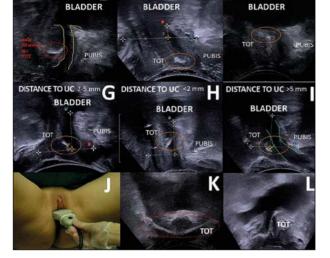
Ultrasound parameters for evaluating the placement and function of tension-free suburethral slings: transperineal ultrasound in the sagittal plane (A), which enables evaluation of the position of a transobturator tape (TOT) at rest (B), and urethral kinking during the Valsalva maneuver (C); position (D, middle third; E, distal third; F, proximal third); distance to the periurethral complex (UC) (G, 3-5 mm; H, < 3 mm; I, > 5 mm); transperineal ultrasound in the transverse plane (J), which makes it possible to evaluate the symmetry of the tape (K, symmetrical; J, asymmetrical).
